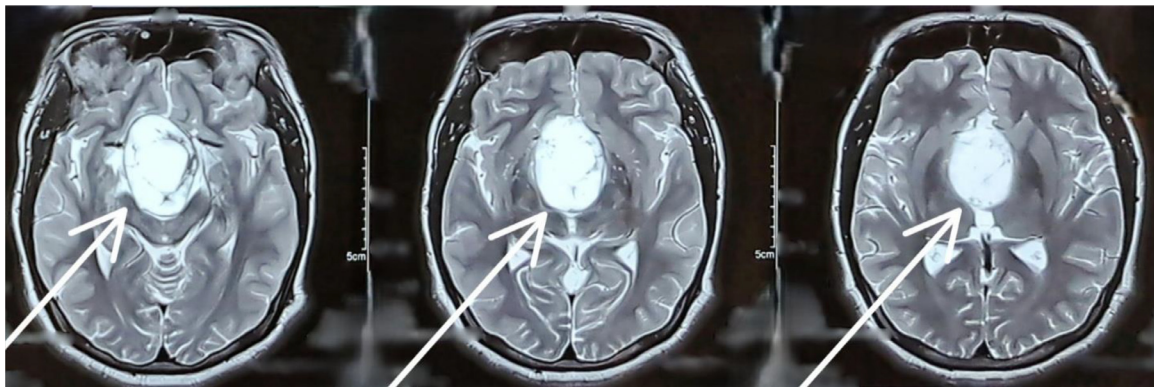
Axial T2-weighted MRI images of the brain showing a hyperintense lesion in the region of the basal ganglia and thalamus, indicated by white arrows. The lesion appears as a well-defined, bright signal, suggestive of a pathology affecting deep brain structure.
